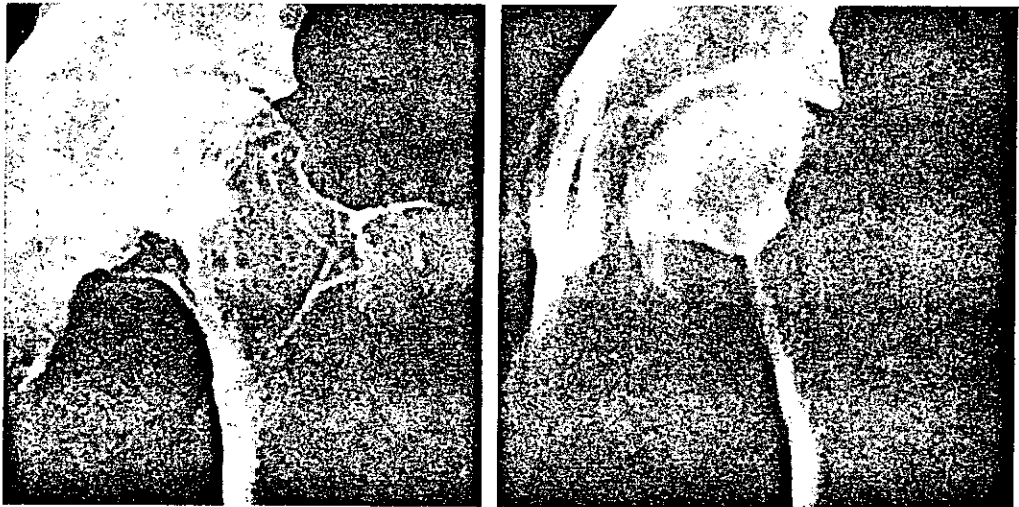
A.P. radiograph and tomograph of the left femoral head showing serpiginous dense layer enclosing a large part of the head of the femur and intact cortex.
